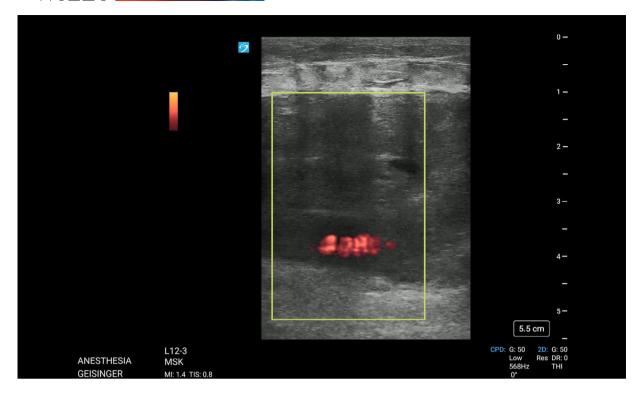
Left thigh echogenicity with power Doppler signal suggesting active extravasation.
